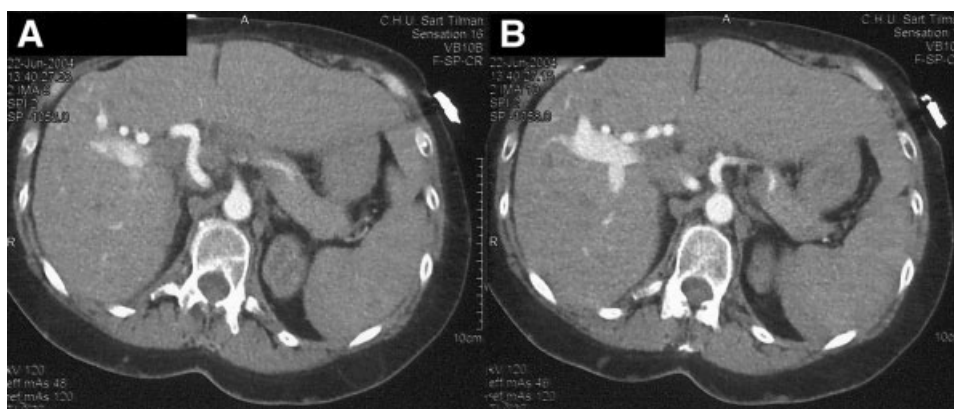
Abdominal computed tomography showing at early arterial phase an enlarged hepatic artery (A) with early and retrograde filling of the portal vein through the right portal branch (B).
